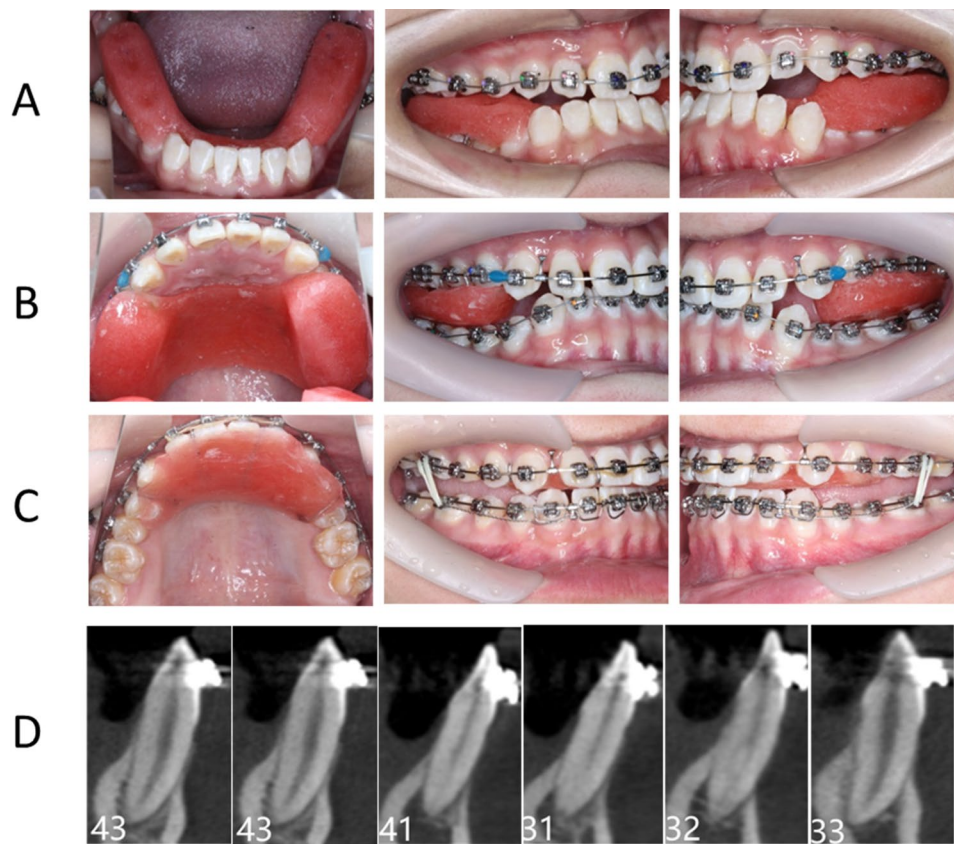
(A,B) Sequential alignment of the upper and lower dentitions; (C) anterior root torquing spring used for lower anterior torque management, and vertical elastics for posterior occlusal contact; and (D) CBCT imaging of the mandibular anterior area taken during treatment progress
